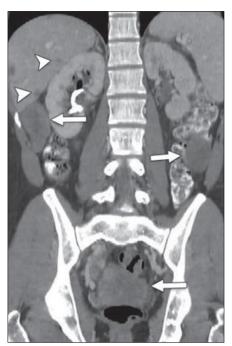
Coronal contrast-enhanced CT image of abdomen and pelvis shows multiple attenuated soft-tissue masses throughout peritoneal cavity and liver metastases [13]
